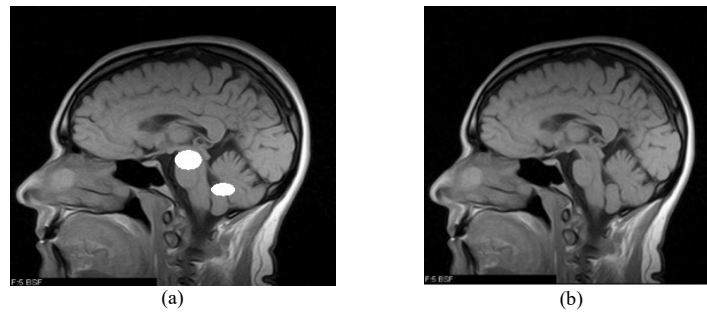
MRI image a) Tampered b) Recovered
